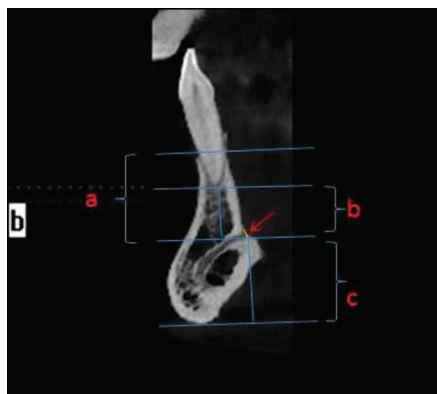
Dimensional measurements on axial mandibular CT sections. A, Distance between crest and lingual foramen. B, Distance between tooth apex and lingual foramen. C, Vertical distance from the mandibular border to the lingual foramen. Arrow: diameter of lingual foramen.
